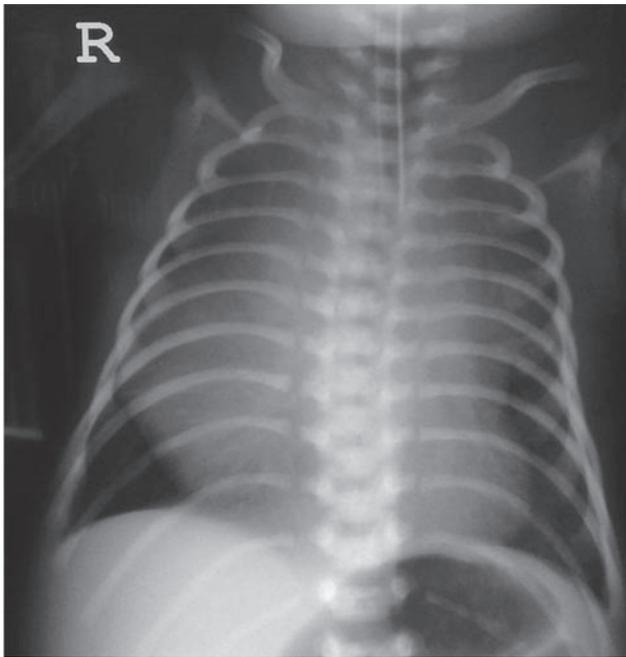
Posterior-anterior chest radiography shows a mediastinal enlargement.
